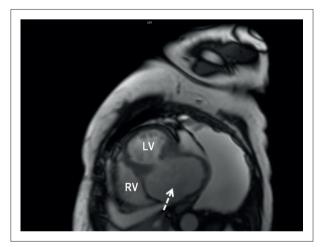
Cardiac magnetic resonance imaging (static cine image, short axis) confirming the presence of a large left ventricular pseudoaneurysm (dashed arrow). RV, right ventricle; LV, left ventricle.
